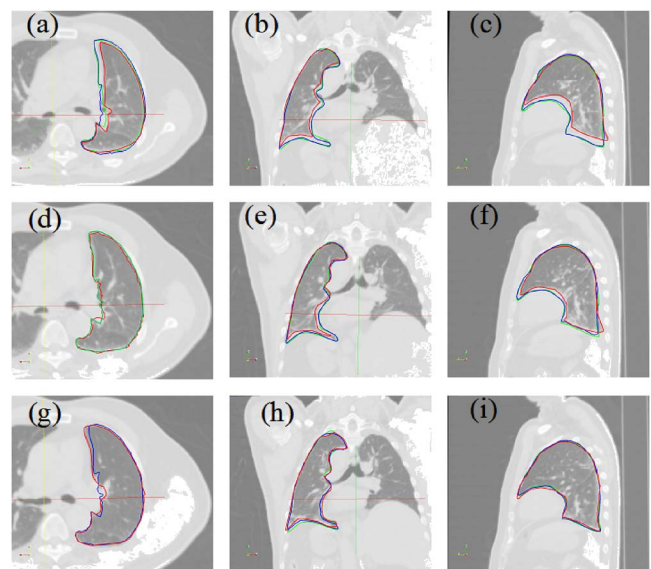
Axial, coronal, and sagittal views of CT images along with lung contours for the first patient. Top row: phase 4; middle row: phase 7; bottom row: phase 10. Rigidly mapped and target contours are displayed. Template contour is also overlaid on displayed phases.
